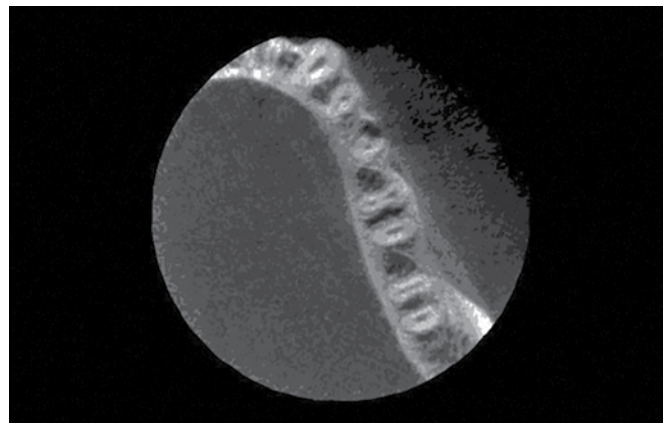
Axial CBCT slice shows the site of perforating internal root resorption
